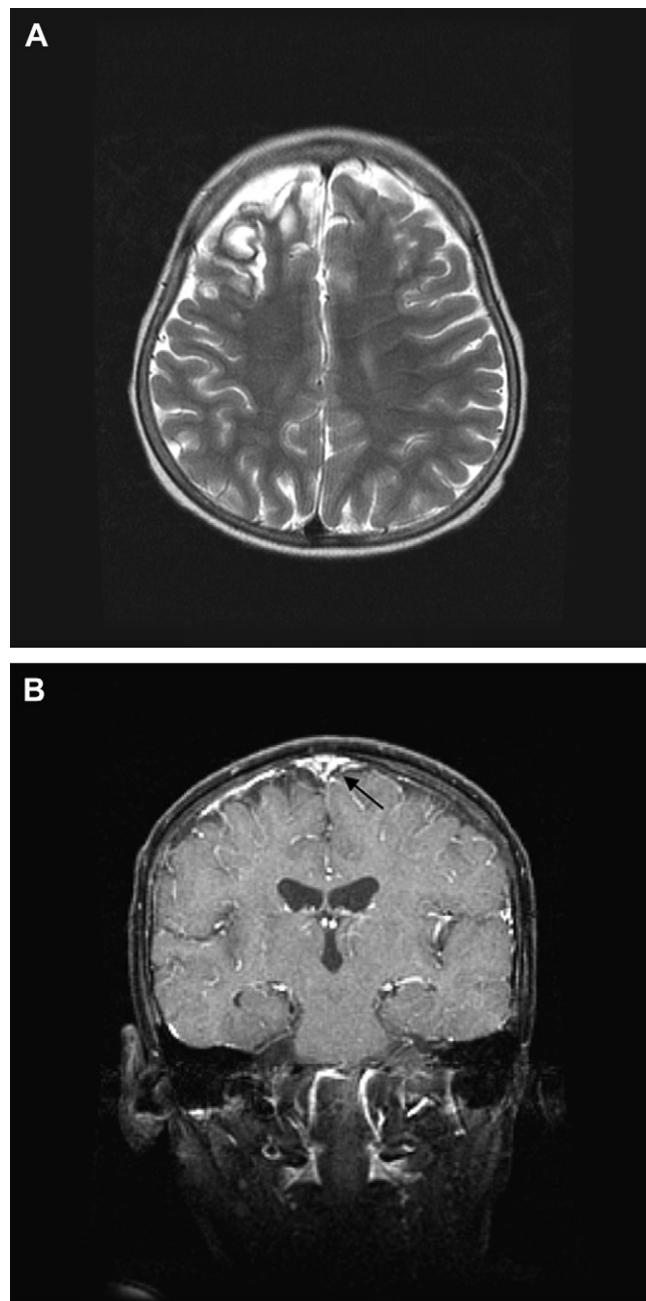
Six months after superior sagittal sinus thrombosis episode. (A) Axial T2-weighted magnetic resonance imaging shows encephalomalacic tissue loss in right anterior high frontal lobe with hemosiderin deposition. (B) Coronal T1-weighted magnetic resonance imaging reveals nearly total resolution of superior sagittal sinus thrombosis.
